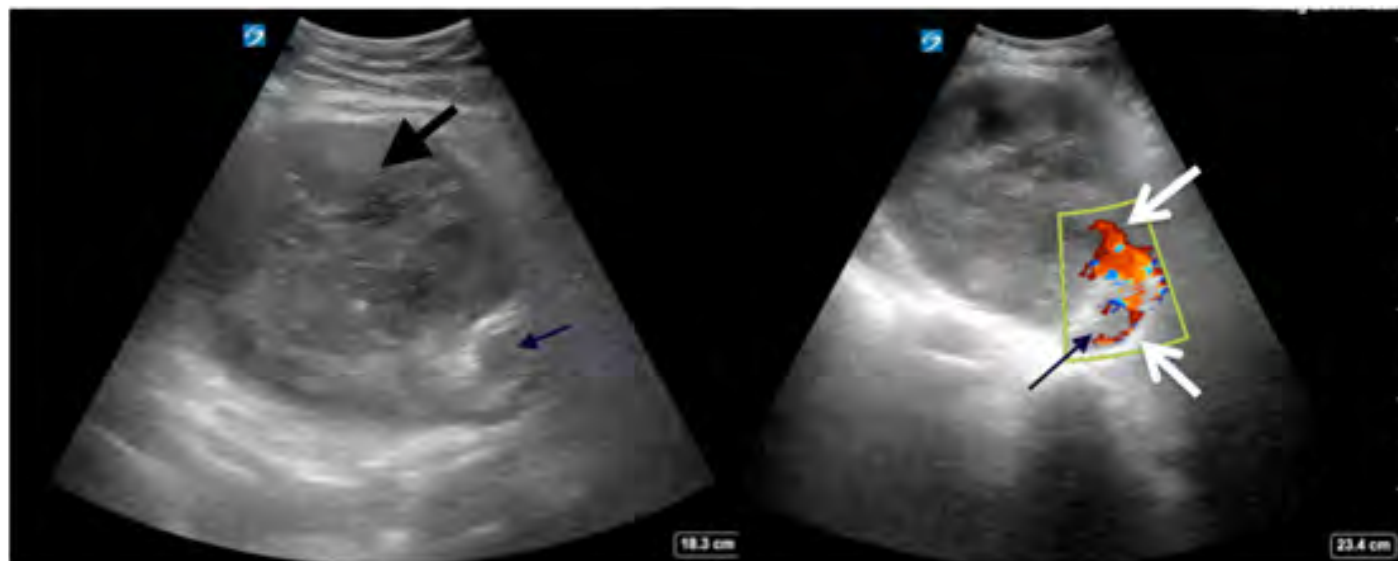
Ultrasound of the left iliac (left) with color Doppler flow (right) showing the true lumen (thin black arrow) and evidence of the leak (white arrows) creating a pseudoaneurysm (thick black arrow).
